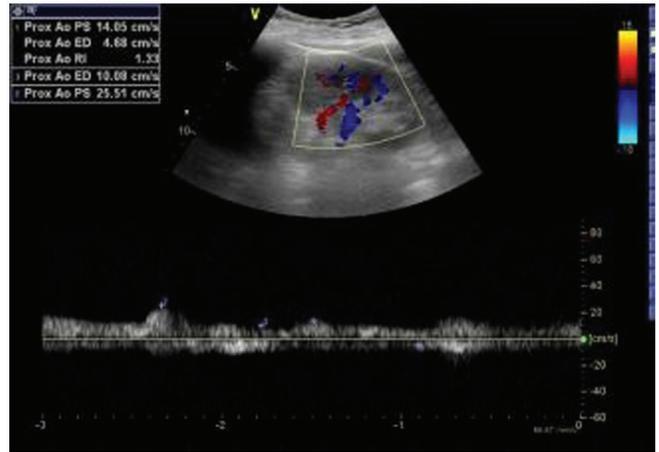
No abnormality in the color Doppler scan of renal blood vessels.
